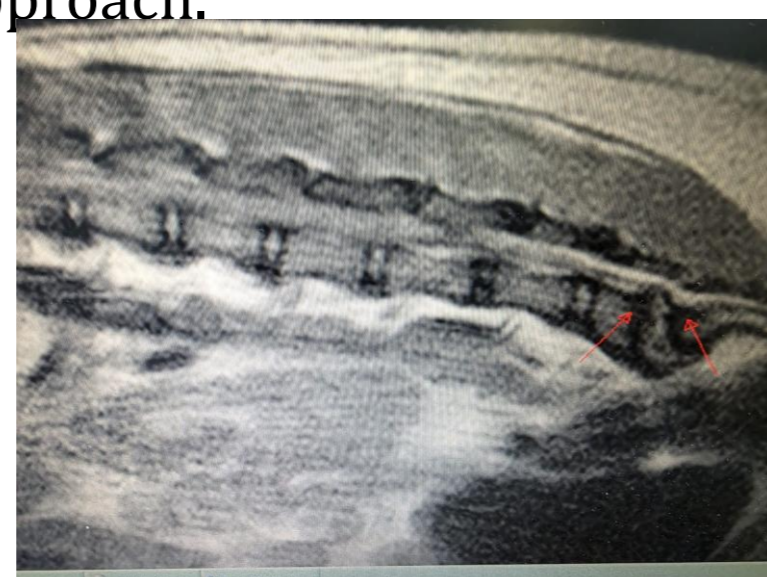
MRI T2 Sagittal showing disc herniation
